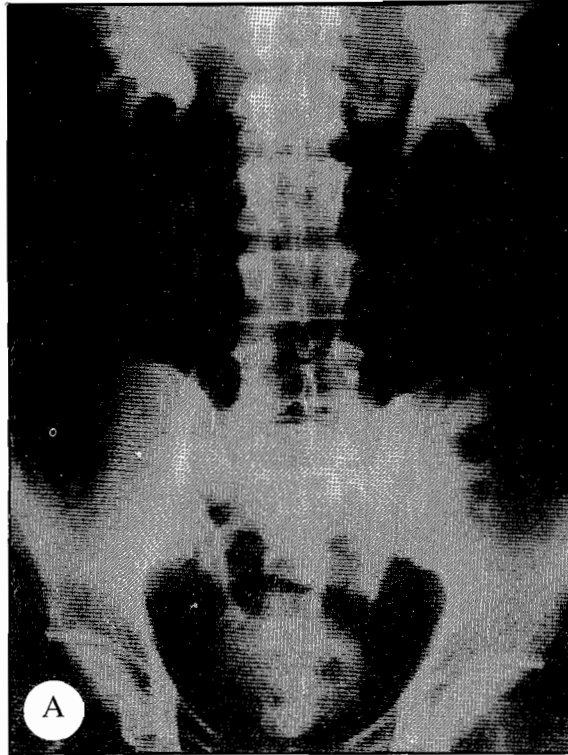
A: Preoperative intravenous urogram. B: Intravenous radiograph showing bilateral ureteral strictures after failure of endoscopic dilatation. C: Intravenous radiograph showing an improved upper tract after open surgical revision.
